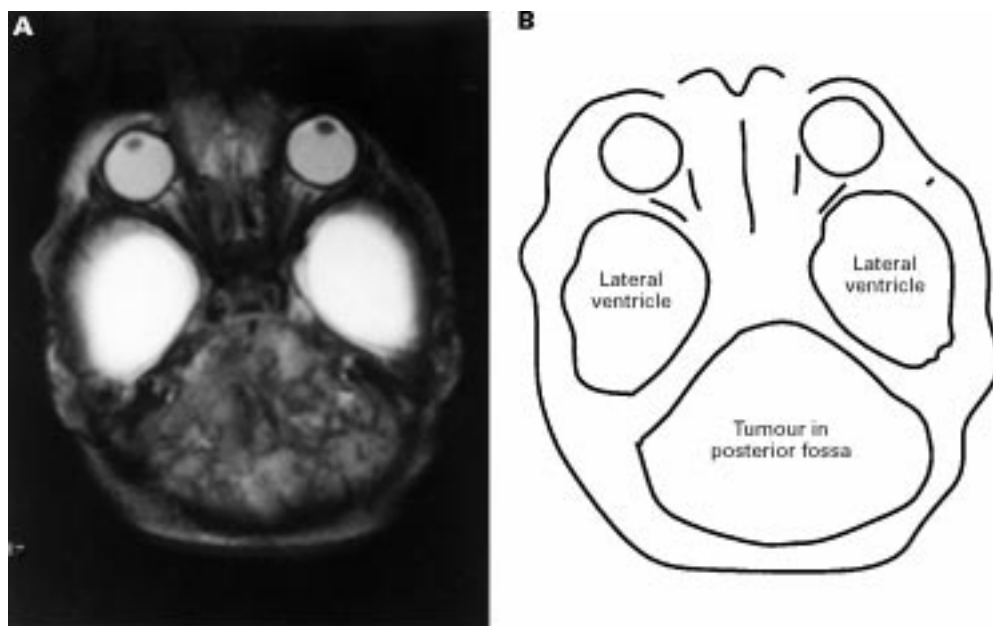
T2 weighted MRI scan (transverse section).
